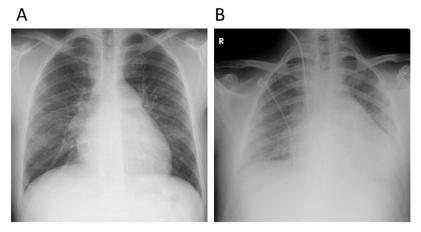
Representative radiographical images of pulmonary edema induced by epoprostenol. (A) Chest X-ray of a patient with pulmonary veno-occlusive disease (PVOD) on admission shows cardiomegaly, dilatation of pulmonary arteries, and Kerley B lines. (B) Chest X-ray of a patient with PVOD after administration of epoprostenol (0.5 ng/kg/min) shows severe pulmonary edema.
